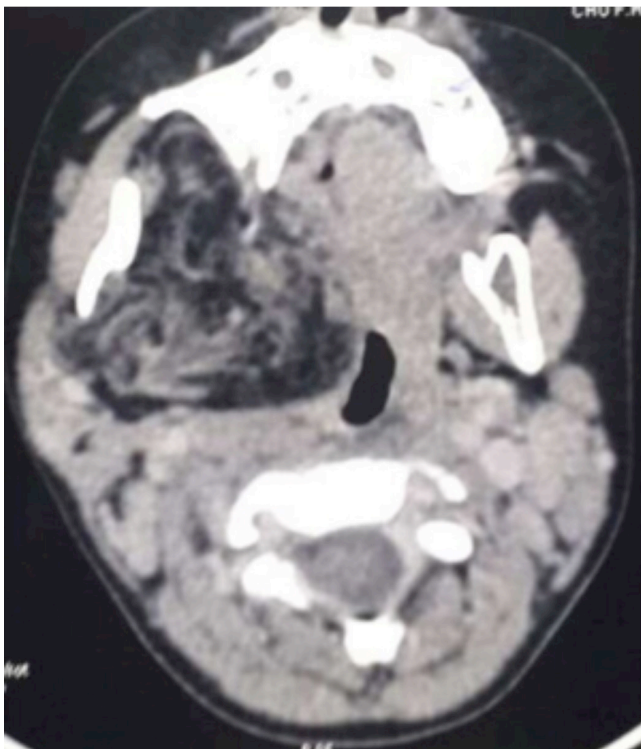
CT scan axial section showing heterogeneous hypodense of the infratemporal fossa
